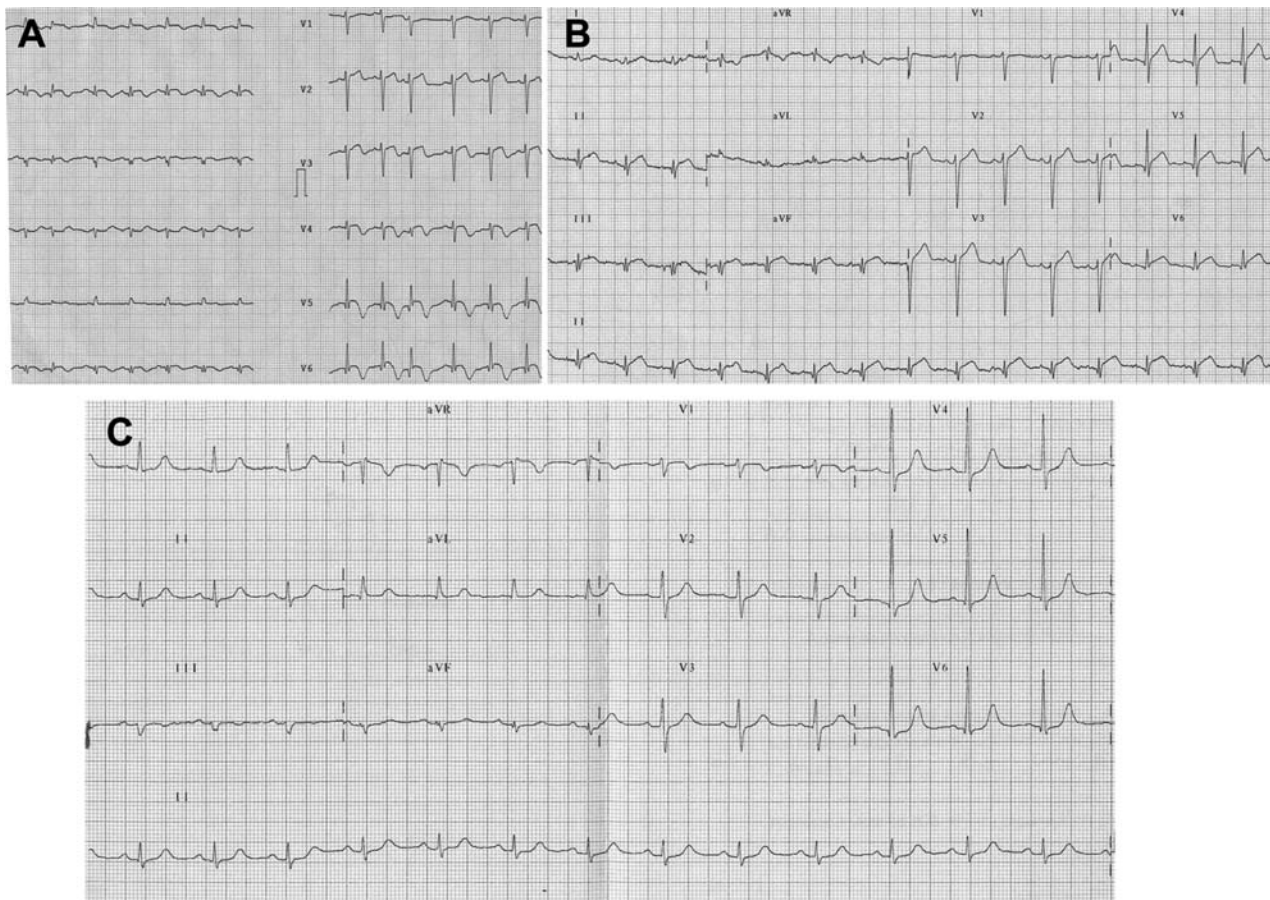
Echocardiography at diagnosis (A), at 1 week (B), and at last follow-up (C).
